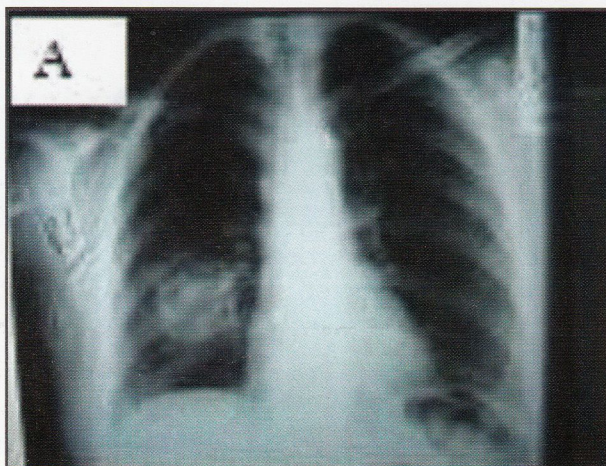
(A) Preoperative chest X-ray showing a lesion in the right hemithorax.
